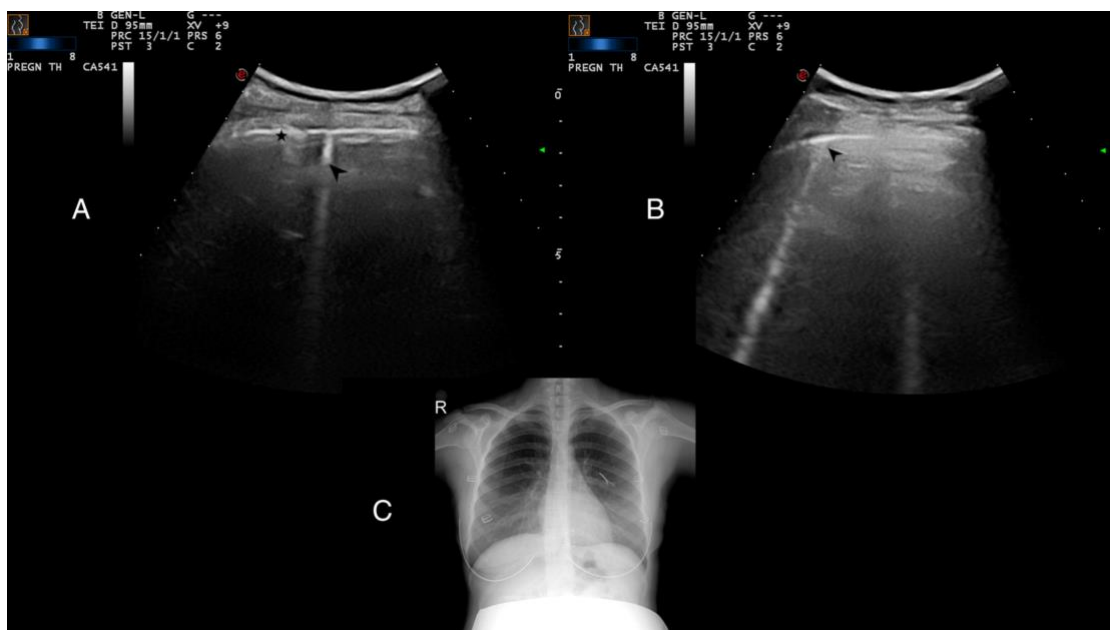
Abnormal LUS findings in an asymptomatic pregnant woman. Landmarks 2, 7, and 12 were classified as score 1. The star indicates the disrupted and thickened pleural line, and a small white area is noticeable below the indent; the arrowhead indicates a sporadic B-line (A). The arrowhead indicates a disrupted and thickened pleural line and a sporadic B-line arising from the pleura, which is a hyperechoic vertical line touching the bottom of the screen (B). Normal chest radiographic findings did not indicate viral pneumonia (C).
